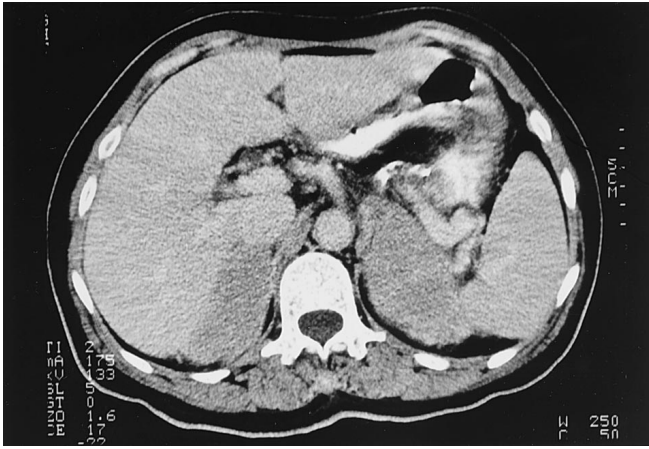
Bilateral adrenal enlargement on initial abdominal CT scan
